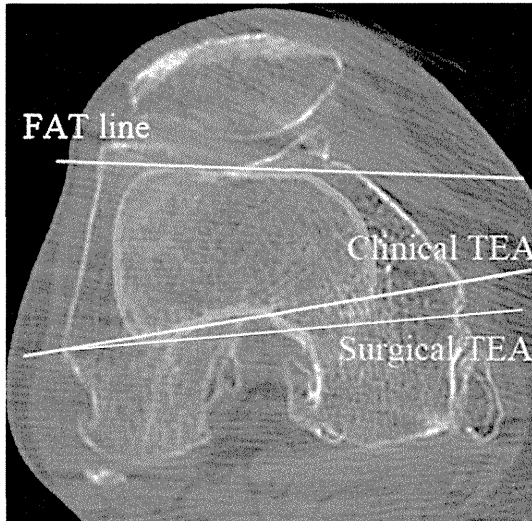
The anterior femoral surface immediately proximal to the trochlea with the FAT line is superposed to the femoral condyle CT slice. The lines indicate the FAT line, clinical and surgical TEA.
